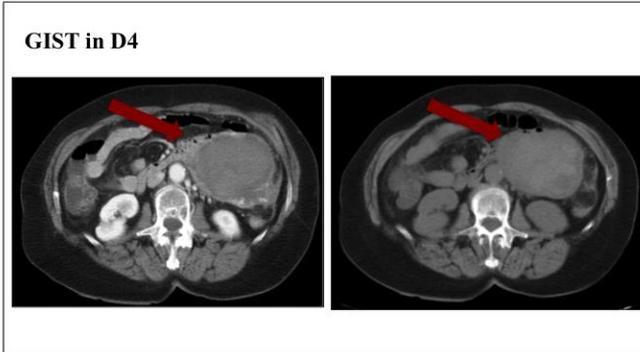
GIST in D4 (Fourth duodenal portion), CT in arterial and venous phases
